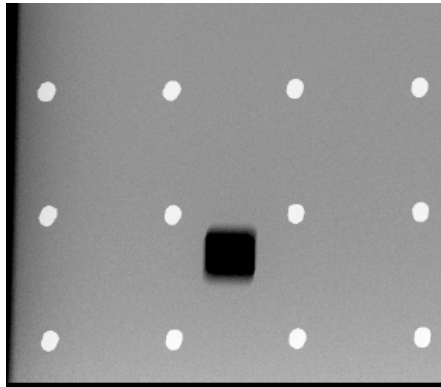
Radiograph of the tissue equivalent slabs. The arrays of white disks are the shadows of beam stops. The CNR values are obtained based on the dark square region of interest.
